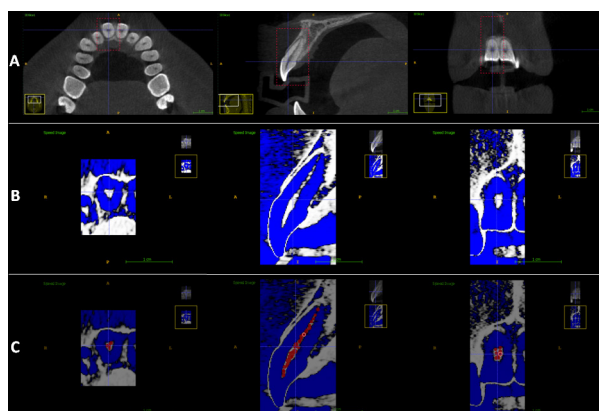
Steps of the segmentation process of a right upper central incisor using CBCT imaging. (a) Selection of the region of interest (ROI) in the axial, sagittal and coronal planes. (b) After adjustment of the default density range. (c) Addition of “seeds” throughout the pulp extension in the axial, sagittal and coronal planes.
